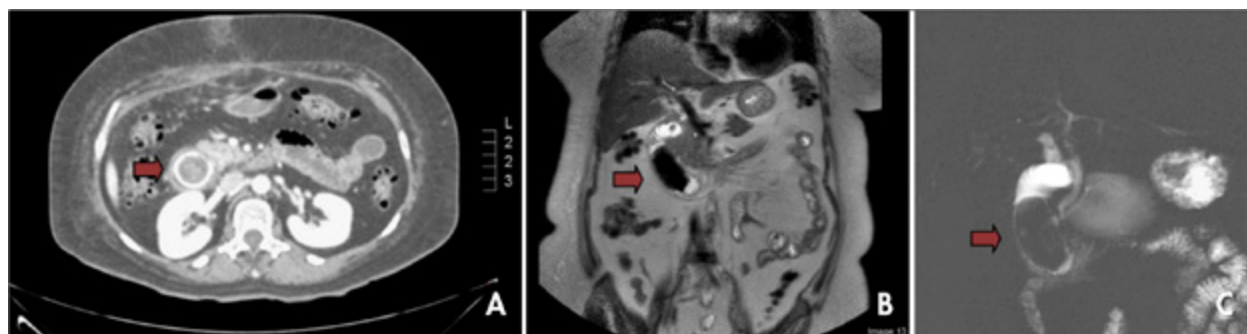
A) Three-phase computed tomography of the abdomen in venous phase; B) and C): T2-weighted SPAIR magnetic resonance cholangiography.
